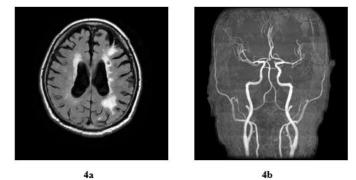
Brain MRI and MRA, 4a. infarcts are found in left frontal and parietotemporal areas 4b. stenosis is found in the M1 of middle cerebral artery (MCA).
